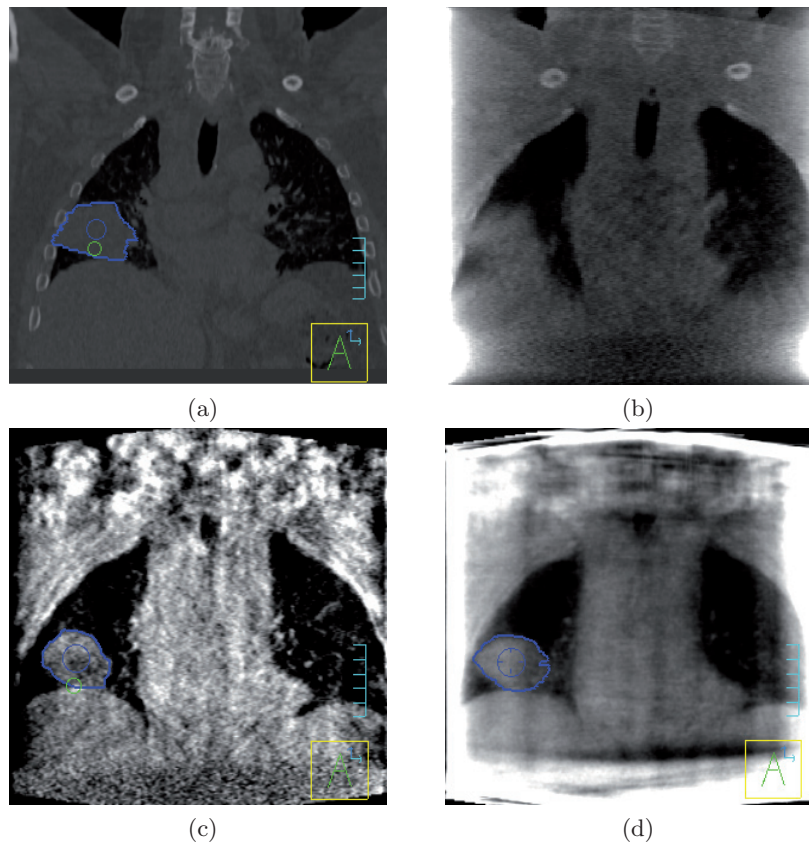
Image reconstruction example slice in coronal view: (a) FE phase of planning CT; (b) FDK-MVCBCT reconstructed from all the projections; (c) FE phase of FDK-MVCBCT; (d) FE phase of ART-MVCBCT. Tumor contour is displayed as blue
